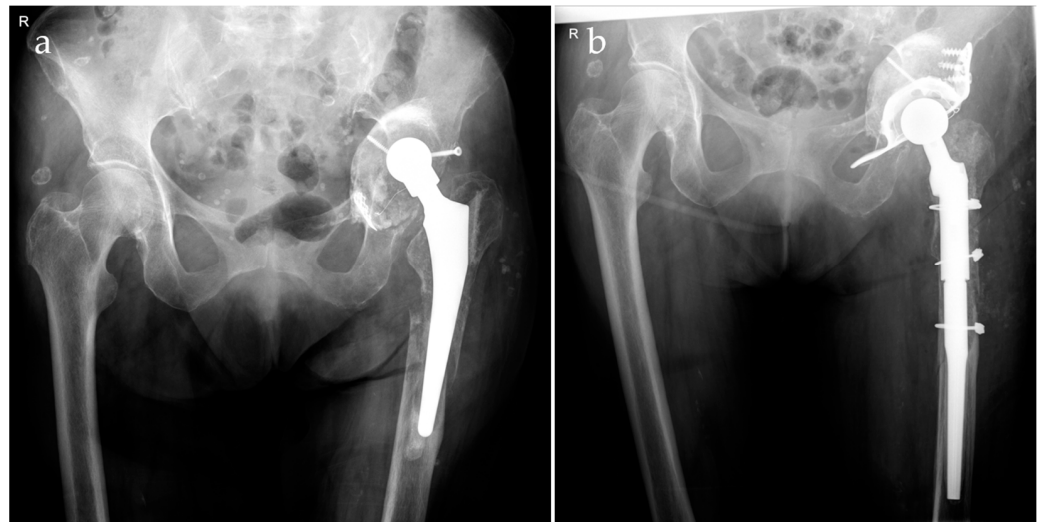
Radiography before megaprosthesis (a); control radiography after megaprosthesis implantation (b).
